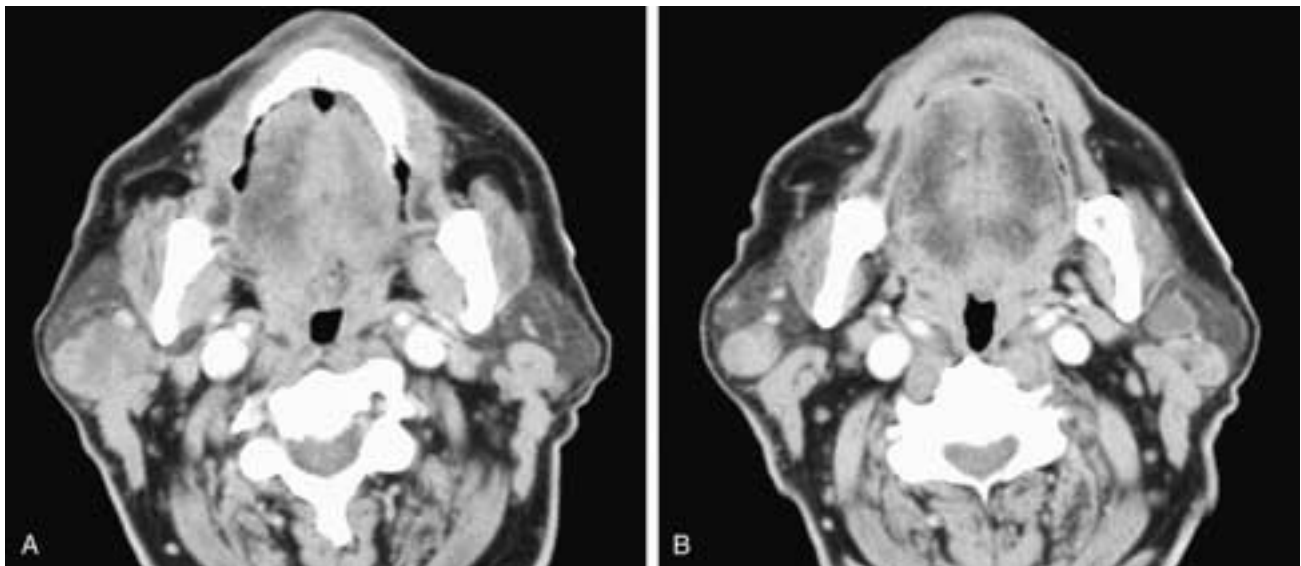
Axial contrast-enhanced CT scans (A, B) show multiple well-defined, partially cystic masses in both parotid glands. This patient had Warthin's tumors.
